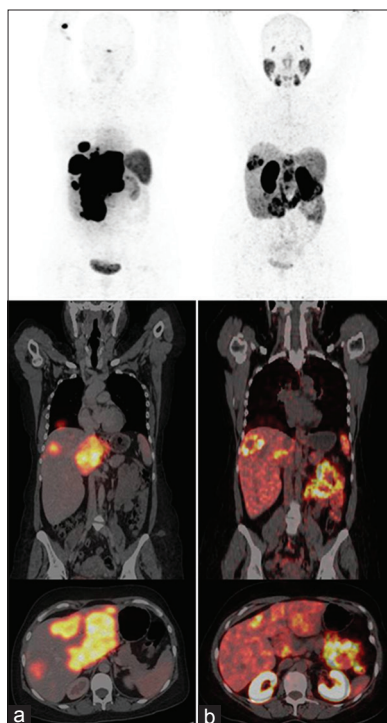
⁶⁸Ga-DOTANOC positron emission tomography-computed tomography (a) and ⁶⁸Ga-prostate-specific membrane antigen-11 positron emission tomography-computed tomography (b) in a case of metastatic pancreatic neuroendocrine tumor, showing increased tracer uptake in multiple liver lesions. However, the intensity of uptake was less in ⁶⁸Ga-prostate-specific membrane antigen when compared to ⁶⁸Ga-DOTANOC images
